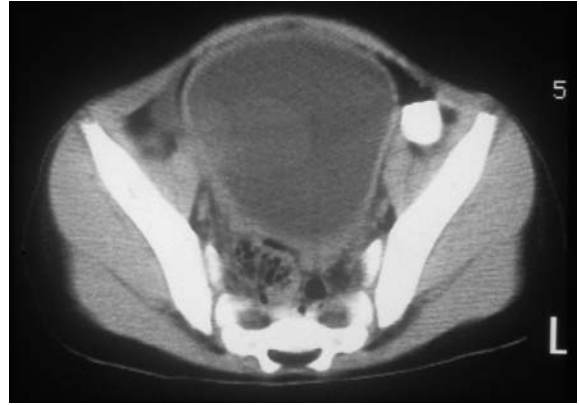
CT scan of the pelvis in a child with rhabdomyosarcoma presenting with an abdominal mass (distended bladder).
